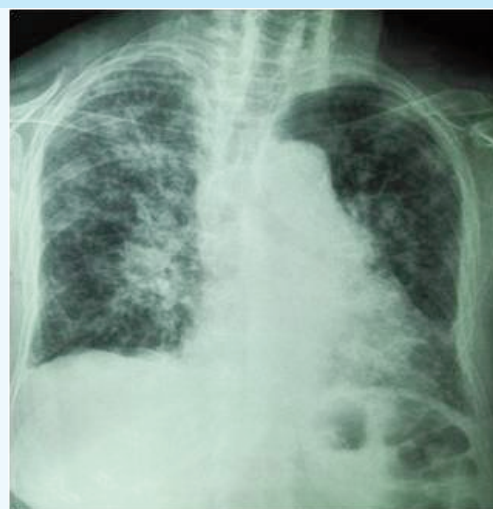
Chest X-ray showing bilateral and diffuse interstitial and alveolar opacities.
